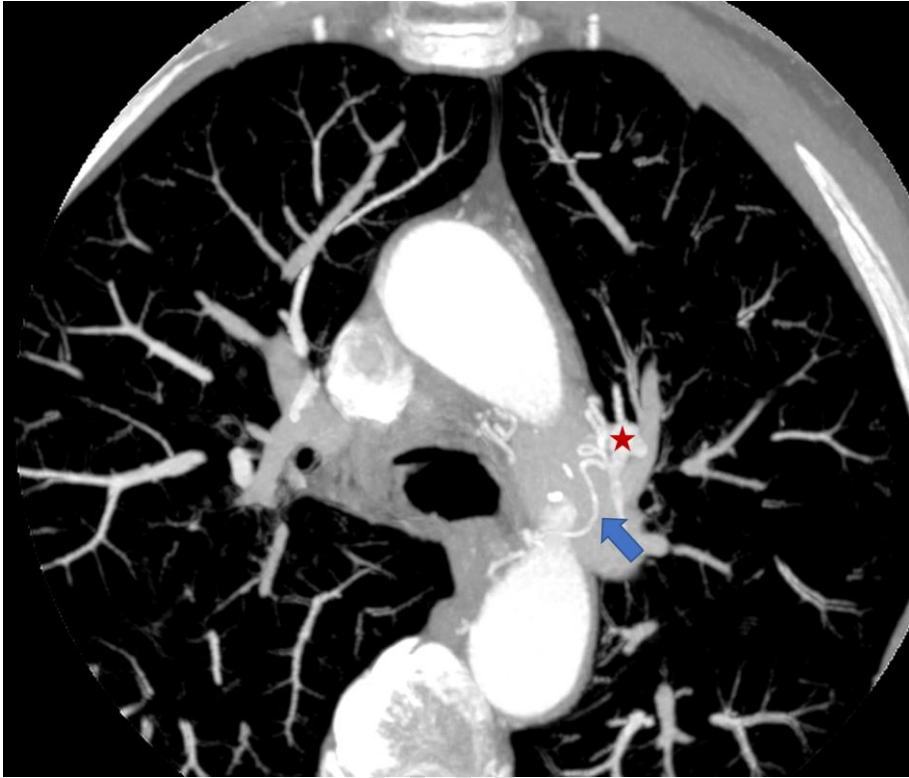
Coronary CT Scan, axial view just under the aortic arch showing the CBF (blue arrow) creating creating an arterial confluence (red star) near the left atrial appendage. MIP 6 millimeters.
